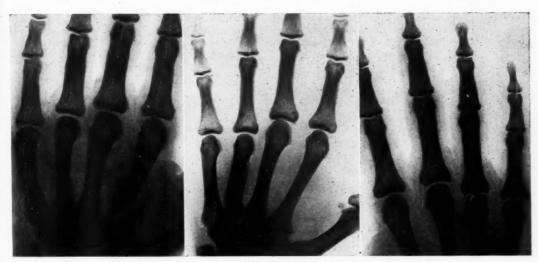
X-ray in Case 1 showing a transverse fracture at the distal end of the fifth right metacarpal.
